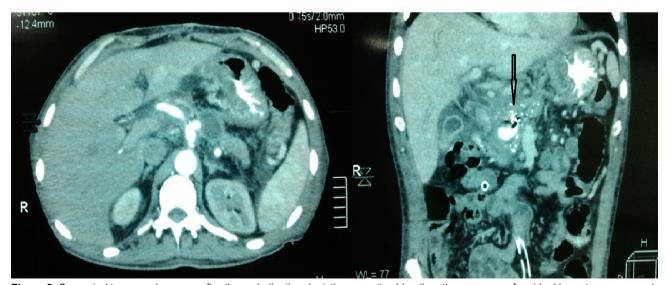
Computed tomography scans after the embolization depicting no active bleeding, the presence of residual hematoma surrounding pancreas body and neck and coils (arrow).
